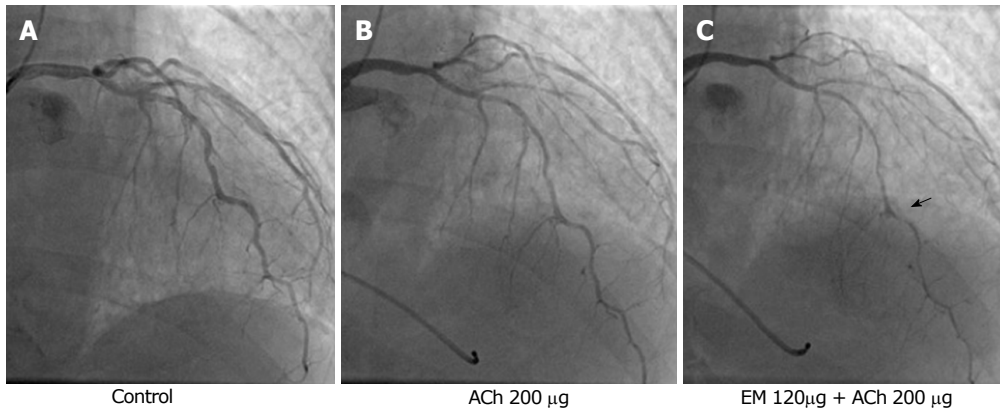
A case of coronary spasm, which was documented by sequential spasm provocation test, which was performed after the routine coronary angiography, vasodilator administration, and preprocedural infusion of nitroglycerin. A: The patient had chest symptoms at exercise early in the morning. Coronary computed tomography angiography showed stenosis of the left anterior descending coronary artery. However, the coronary angiography showed no significant coronary stenosis; B: Because the presence of vasospastic angina was suspicious, the spasm provocation test was performed despite the intracoronary infusion of nitroglycerin and calcium channel blocker intake. The standard doses of acetylcholine (ACh, up to maximal 200 µg) did not cause coronary spasm; C: Consequently, we performed the sequential spasm provocation test: 120 µg of ergonovine maleate was infused first followed by 200 µg of ACh, showing the presence of coronary spasm (right panel) and obtained the diagnosis of vasospastic angina. The spastic site was indicated by an arrow. Ach: Acetylcholine; EM: Ergonovine maleate.
